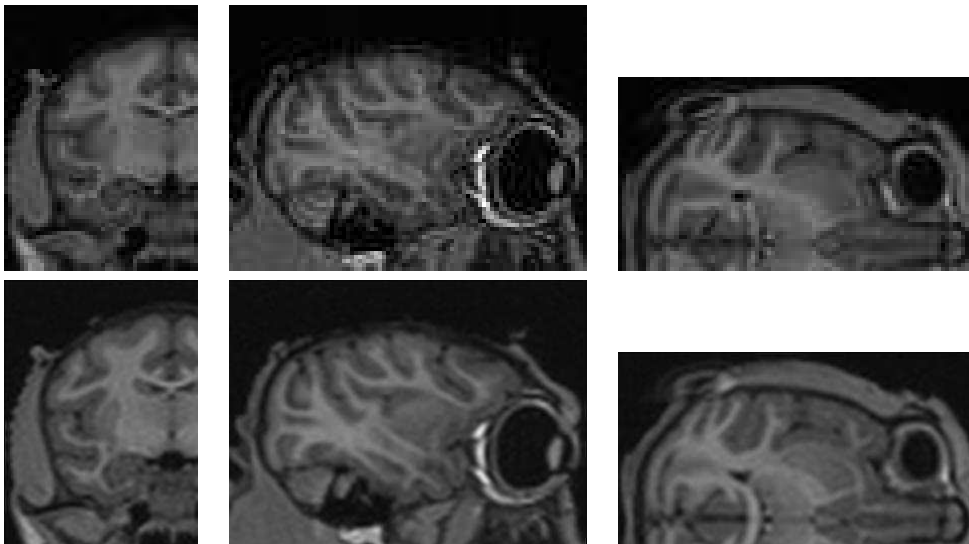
Top row: a region of interest (ROI) from the original MR image centered on the right hemisphere. Bottom row: this ROI supersampled by a factor 4 with cubic splines.
